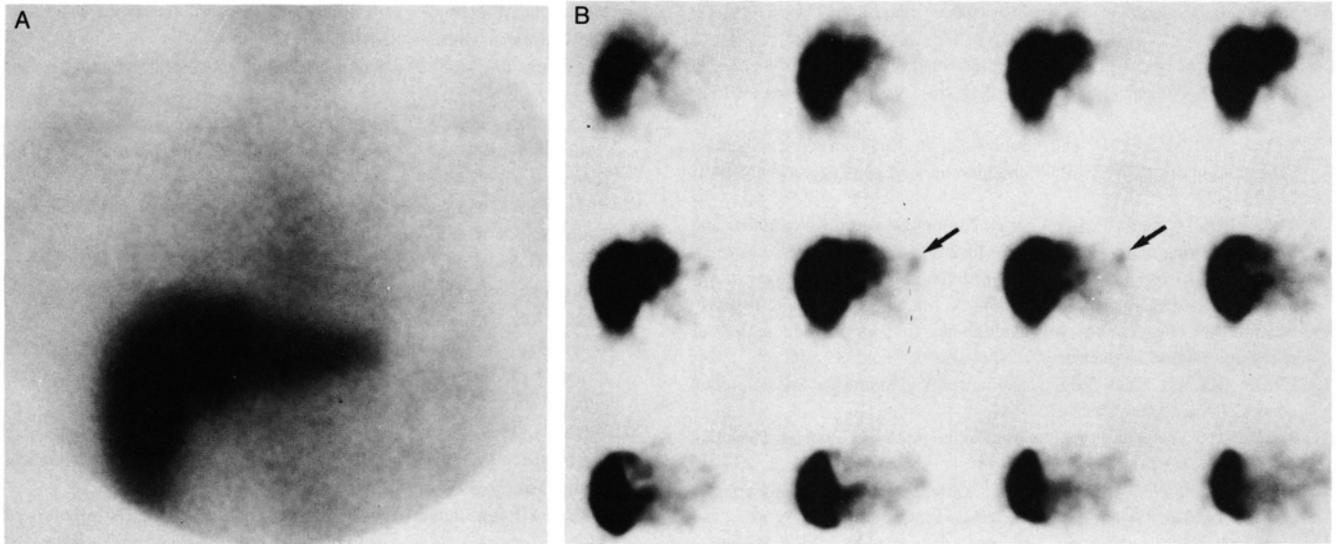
Images of 42-yr-old man, status post transverse colectomy and splenectomy for colon carcinoma. Computed tomography (CT) scan 1 yr after surgery shows new finding of 3-cm metastasis centrally located in right lobe of liver. ^{111}In -labeled CYT-103 study was undertaken to identify any extrahepatic metastases in patient who was candidate for resection of hepatic lesions. (A) Anterior view planar image of chest and upper abdomen at 120 hr in addition to all other planar views was normal. (B) Sequential transaxial SPECT images through liver and upper abdomen show faint but definitely abnormal uptake in left upper quadrant (arrows). CT did not identify left upper quadrant tumor, but extrahepatic metastatic disease at this site was confirmed at time of laparotomy. (Reprinted by permission of Reference 8.)
